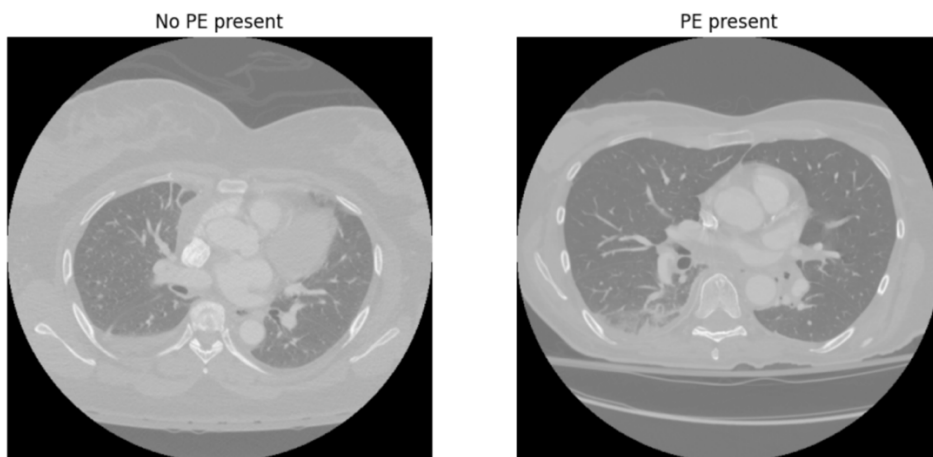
CT images from the dataset showing both a diseased patient (with PE) and a healthy patient (without PE).
